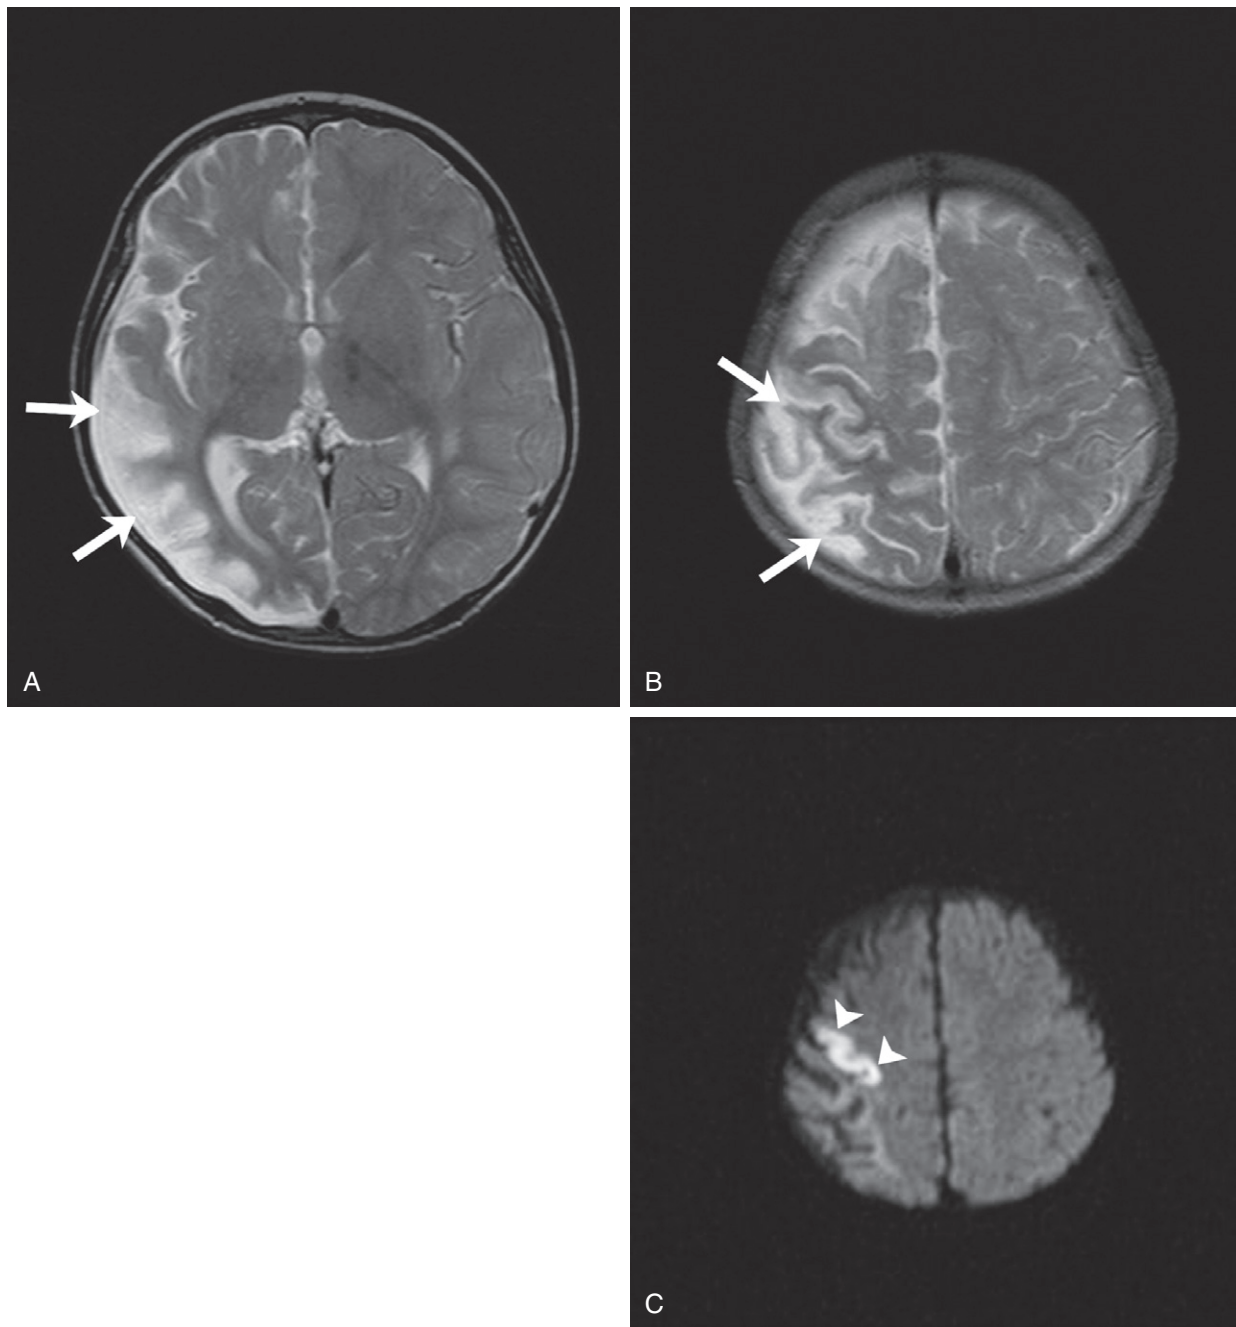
Remote and acute infarcts. Axial T2-weighted MRI (A and B) shows cerebral volume loss with encephalomalacia and gliosis (arrows) associated with an old stroke in this child with new onset of progressive left-sided weakness. Diffusion-weighted MRI (C) reveals a new area of infarct (arrowheads) at the edge of the remote abnormality.
